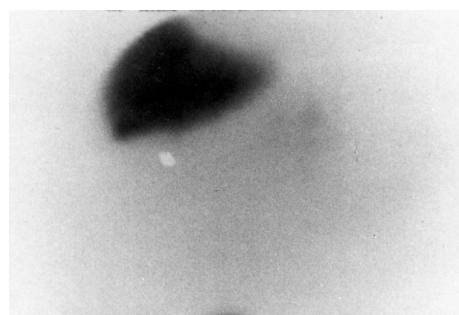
Sequential static scintigram (60 seconds duration) obtained 60 minutes after intravenous application of ^{99m}Tc diethyl iminodiacetate acid, showing uniform hepatic uptake, with very discrete excretion in hepatobiliary system (discrete gallbladder visualisation).
